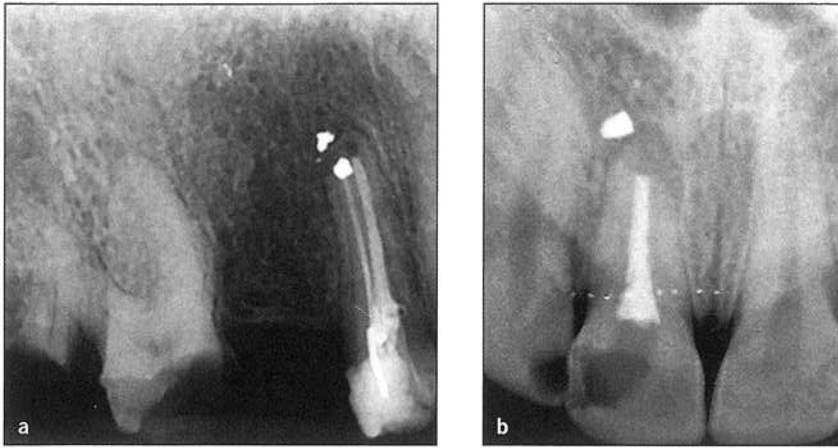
(a and b) Displacement of amalgam when placed as a root-end filling, potentially causing periapical leakage and failure of periapical surgery.
